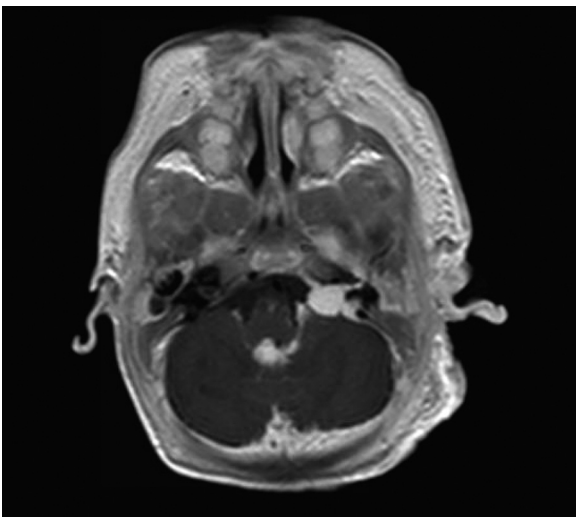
Axial T1 weighted post-gadolinium MRI of the brain demonstrating intracranial hemangioma within the cerebellopontine angle (CPA) coursing along the facial nerve within the internal auditory canal (IAC) toward the geniculate ganglion.
